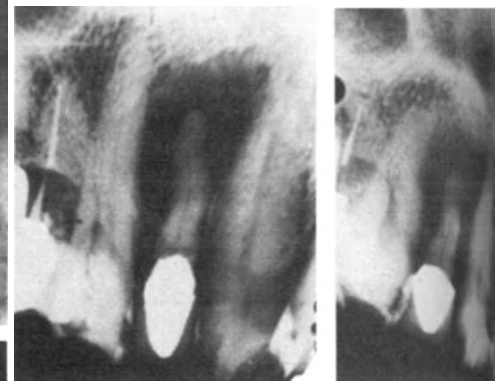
Left, elongation causes enlarged shadow; whereas foreshortening in radiograph on right reduces radiolucent area. Radiolucency is due to anatomic depressions with variations in bone thickness on labial aspect in maxilla. Tooth is vital.
